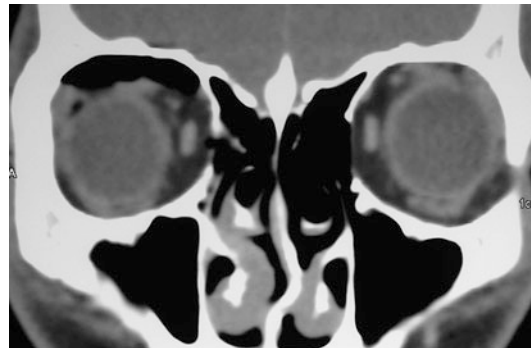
Axial CT scan of orbit showing right orbital emphysema due to fractured lamina papyracea
